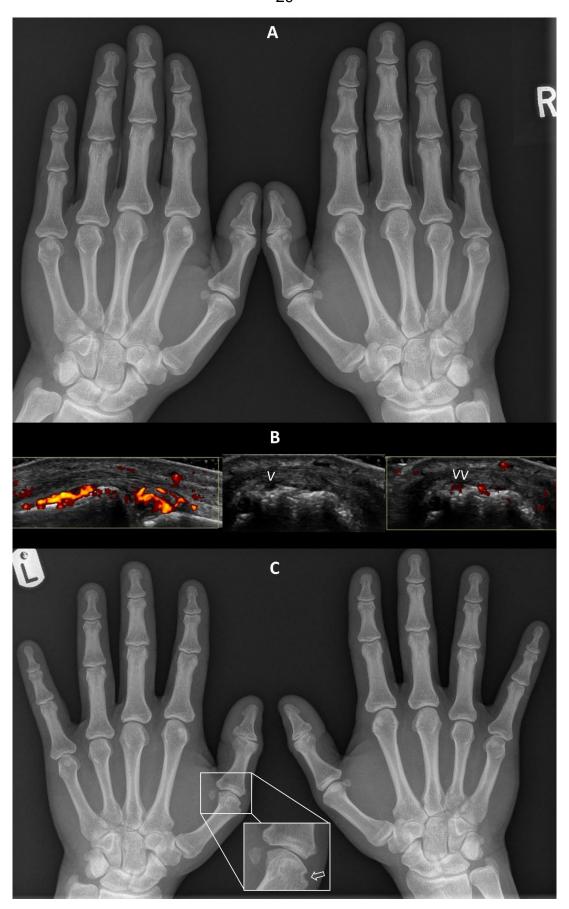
Conventional Radiography and Ultrasound Scan Imaging of Active Psoriatic Arthritis
